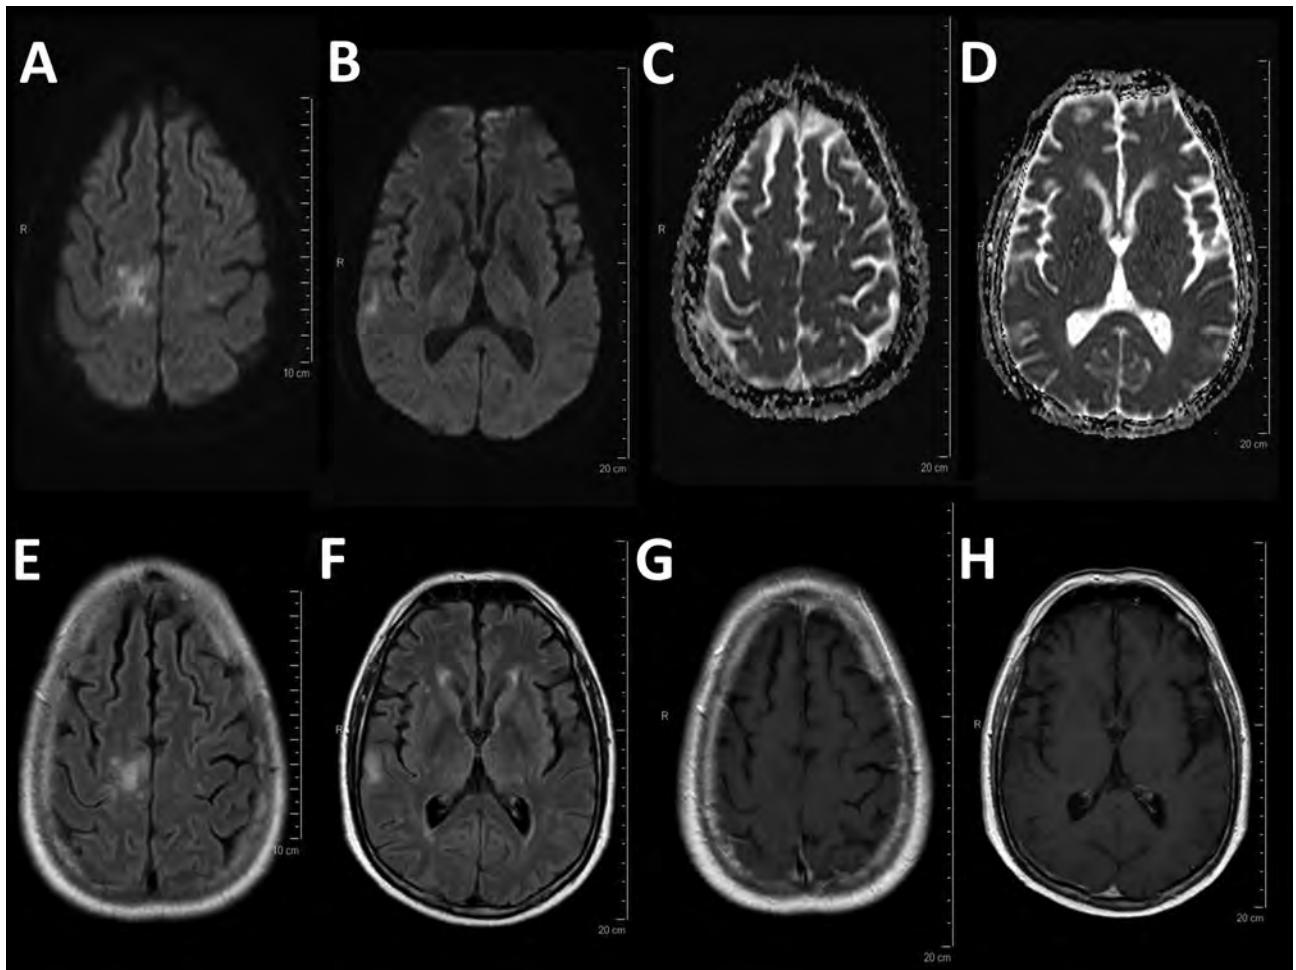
Magnetic resonance imaging for a 54-year-old man with progressive multifocal leukoencephalopathy after treatment with nivolumab, showing typical multifocal lesions: diffusion weighted imaging hyperintensity (A, B) with no decrease in the apparent diffusion coefficient (C, D), corresponding patchy corticosubcortical hyperintensities on fluid-attenuated inversion recovery image (E, F) without enhancement on T1-weighted imaging after administration of gadolinium (G, H).
